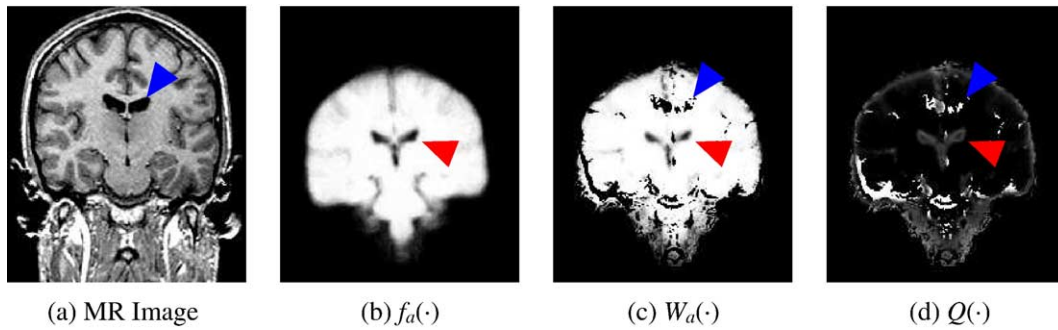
We applied the EM approach to the MR image (a) and the misaligned spatial atlas of white matter and gray matter in panel (b). The result of the analysis is shown in panel (c), which is the weights  $\mathcal{W}$  of the E-Step, and (d), which is the initial objective function  $Q(\cdot)$  of the M-Step. The impact of the misalignment between atlas and image space is especially apparent in the region of the ventricles, whose location are pointed out in the image space and in the atlas space by arrowheads.
